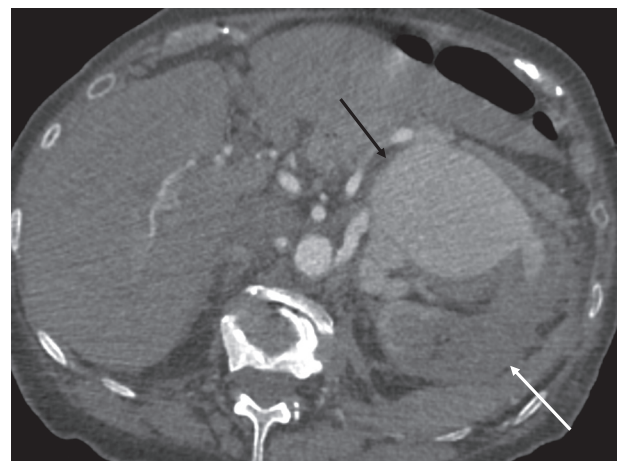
Computed tomography angiogram demonstrating a 7 x 6 cm ruptured left renal artery aneurysm (black arrow) associated with retroperitoneal hematoma (white arrow).
